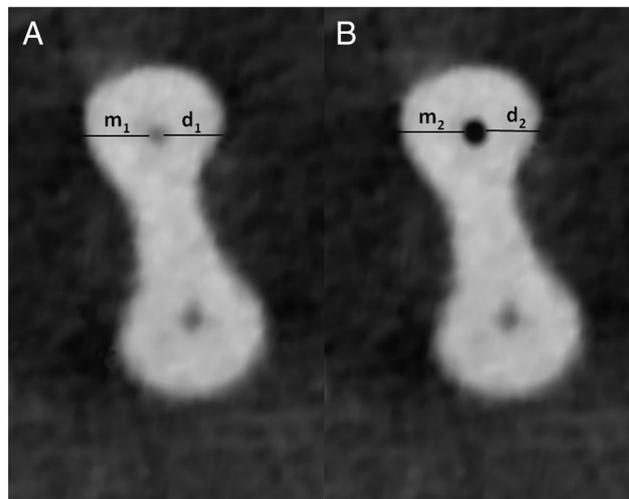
(A) Preinstrumentation and (B) postinstrumentation CBCT images with markings showing points of measurements used for determination of canal transportation and centering ratio.
